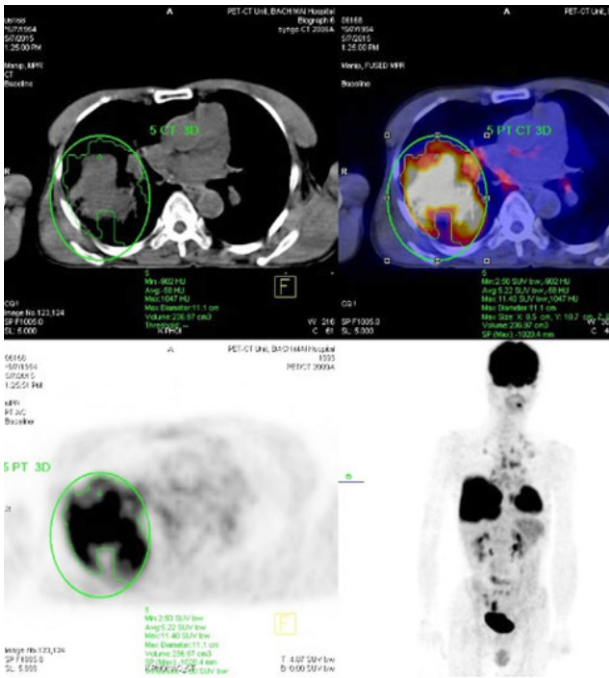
The primary tumor located at upper right lobe with tumor diameter was 11.1 cm and SUVmax was 11.40.
